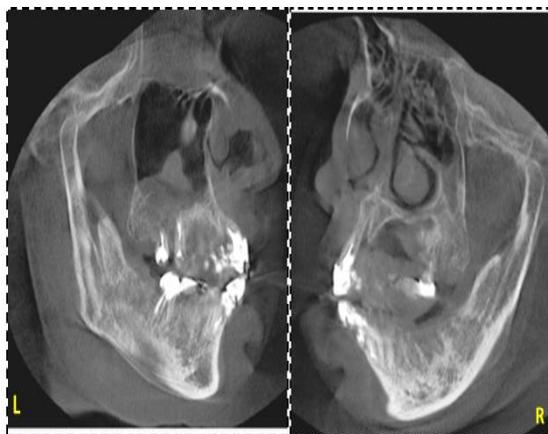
CBCT (lateral view) showing the relation of condyles in the condylar fossa.
